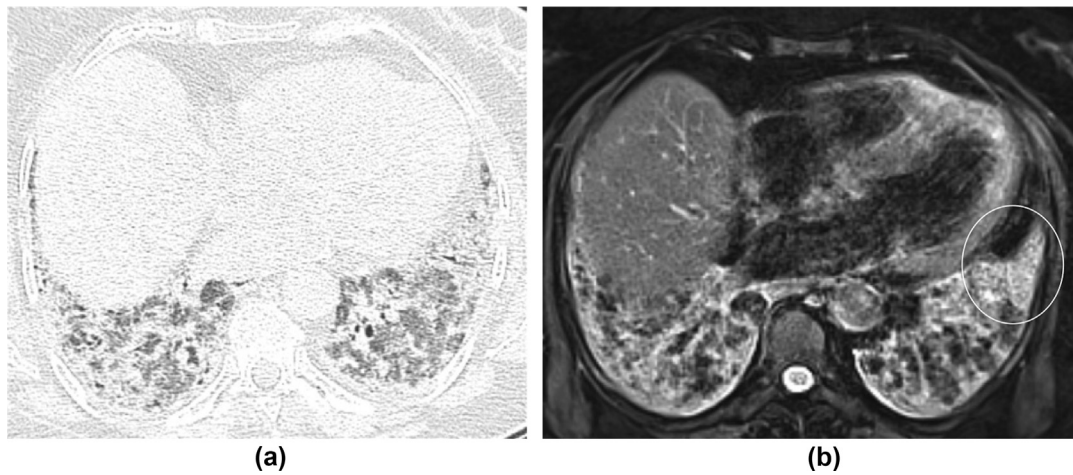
MRI is able to provide additional information regarding tissue characterisation. In a patient with anti-synthetase syndrome, fast spin echo fat-saturated T2-weighted MRI image shows areas of increased signal intensity likely to represent inflammation (circle in b).
